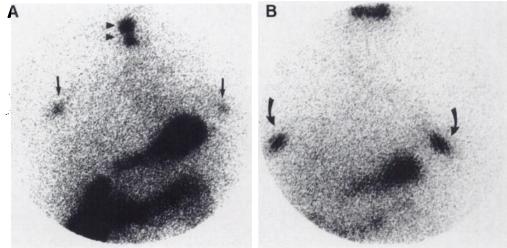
(A) lodine-123 diagnostic scan. Anterior chest view obtained 18 mo after discontinuation of breastfeeding. Arrows delineate ++, focal and +, focal uptake, in the right and left breasts, respectively. Black triangles delineate two foci of remnant thyroid tissue. (B) Anterior chest view of a 5550-MBq <sup>131</sup>I postablation scan obtained 5 days after the scan in (A) and after inadvertent administration of CT contrast material for an unrelated study. There is a disappearance of thyroid uptake and persistent breast (curved arrows) as well as submandibular gland uptake.
